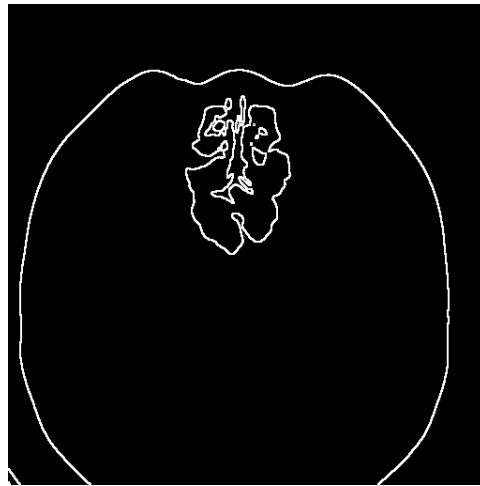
Extracted surface data of CT slice.
